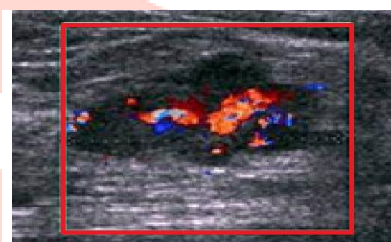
Breast containing tumour obtained from Colour Doppler.
